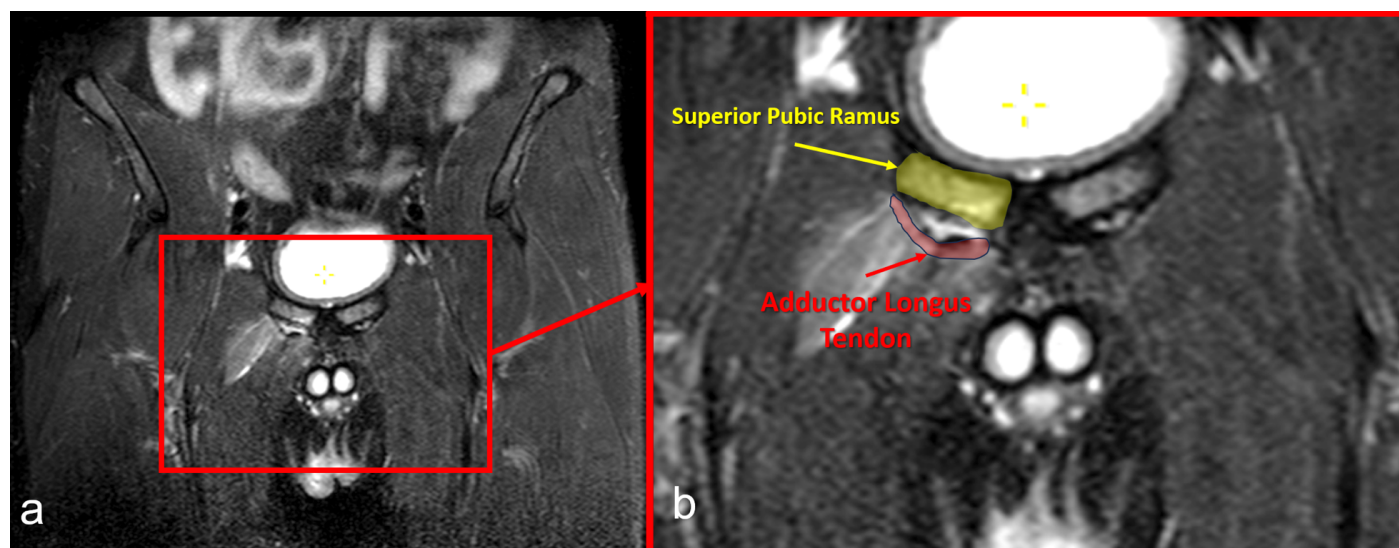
Coronal T2-weighted MR images demonstrating a Type 2 adductor lesion (tendon avulsion) in a football player. (a) Overview image showing disruption at the level of the pubic symphysis. (b) The magnified view of the affected area highlights the retracted adductor longus tendon (red label) and the adjacent superior pubic ramus (yellow label). A hyperintense area consistent with hematoma and soft tissue edema is present between the symphysis and the retracted tendon, typical of tendon avulsion injuries.
